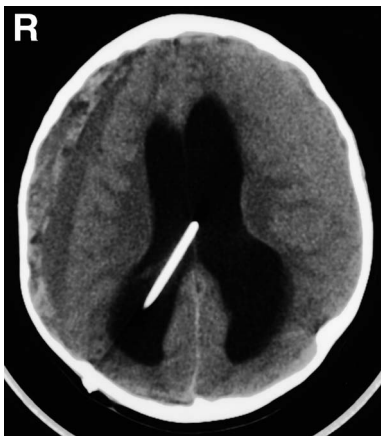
Computed tomography scan obtained at follow-up examination 51 days after ventriculoperitoneal shunting showing right subdural hematoma.
